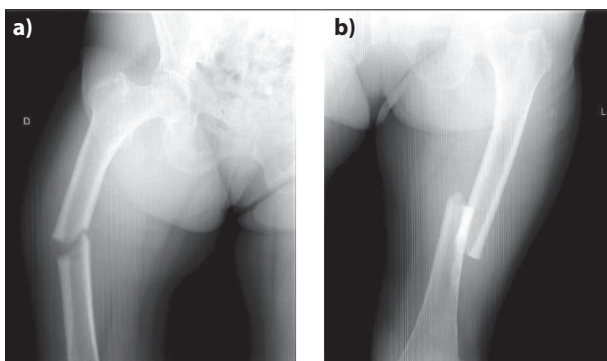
Radiographs showing complete fracture at the diaphysis on the right (a) and left (b) femur
